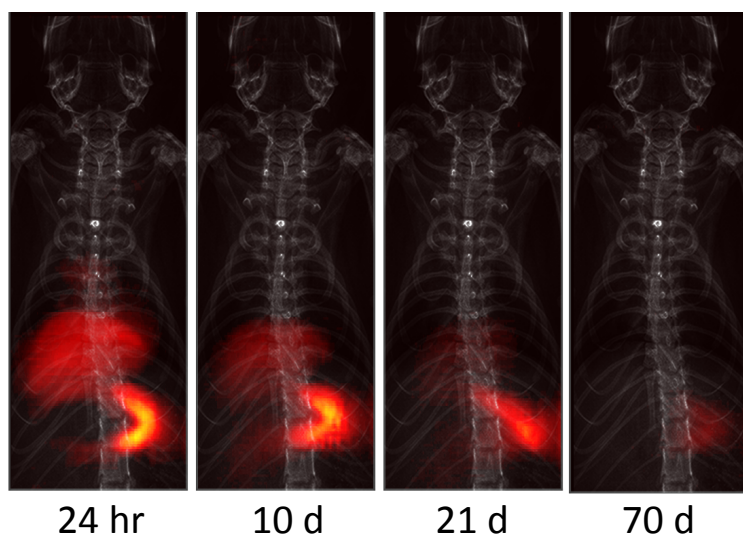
Long-term clearance MPI Images overlaid on a projection X-ray for Ferucarbotran and LodeSpin (LS-008). Ferucarbotran is mostly cleared by the liver, while LodeSpin (LS-008) is mostly cleared by the spleen.
